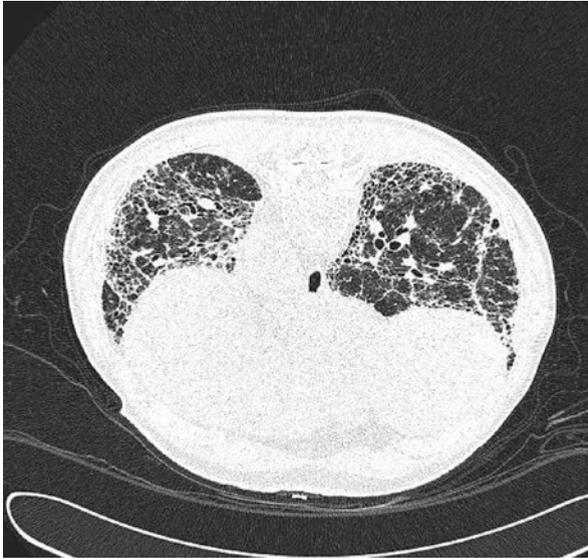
Imaging of IPF. High-resolution CT scan (*HRCT*) of an 82-year-old male patient with advanced IPF. The image, acquired prone, shows evidence of severe basal fibrosis in a typical subpleural distribution, minimal “ground-glass” change, “honeycomb” lung, and secondary bronchial dilatation. The patient had presented with progressive breathlessness and dry cough. Lung function tests confirmed severe intrapulmonary restriction with low lung volumes and impaired gas transfer. The patient developed worsening respiratory failure and died 18 months from presentation
